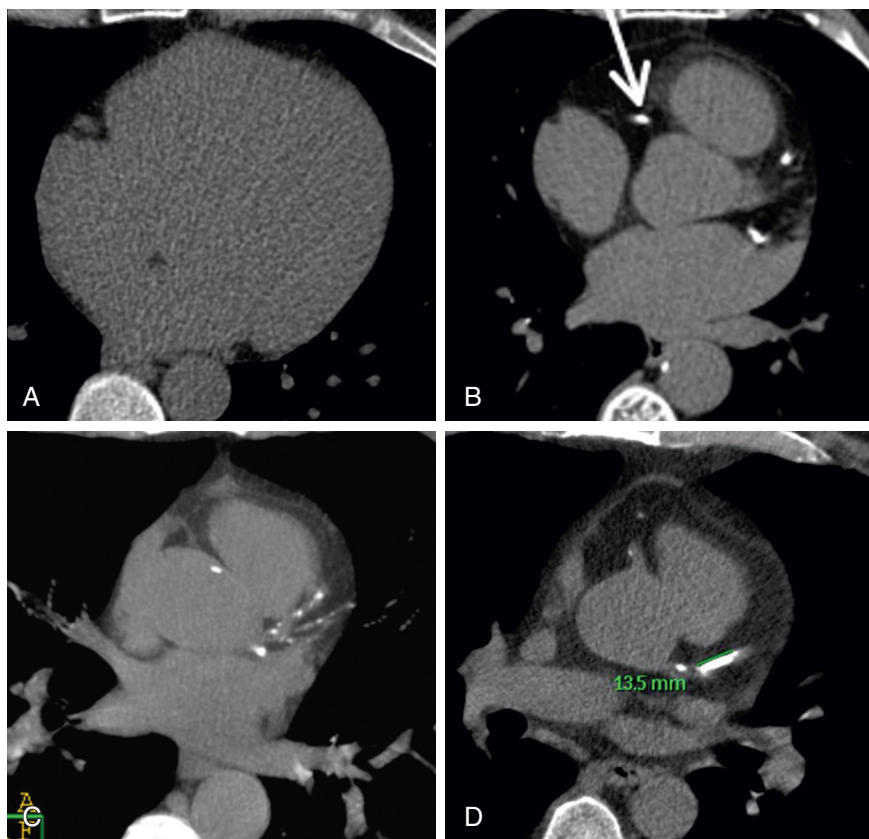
Distribution of coronary calcium on cardiac CT in four different patients: A, no detectable coronary calcium; B, coronary calcium in all three epicardial coronary arteries including (clockwise) the right coronary artery (arrow) and the left anterior descending and left circumflex coronary arteries; C, a "spotty" or diffuse pattern with multiple small (<3 mm) foci of coronary calcium; and D, a large calcified lesion in the left anterior descending coronary artery.
